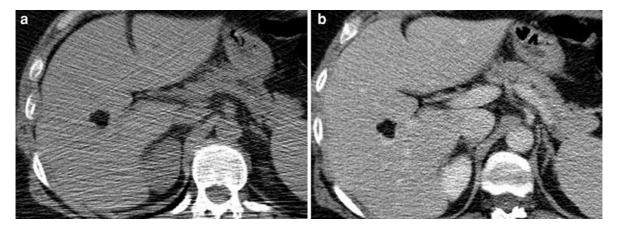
Hepatic lipoma. a Transverse unenhanced CT image demonstrates a small, well-circumscribed, fat density lesion in the right hepatic lobe. b Corresponding contrast-enhanced CT
